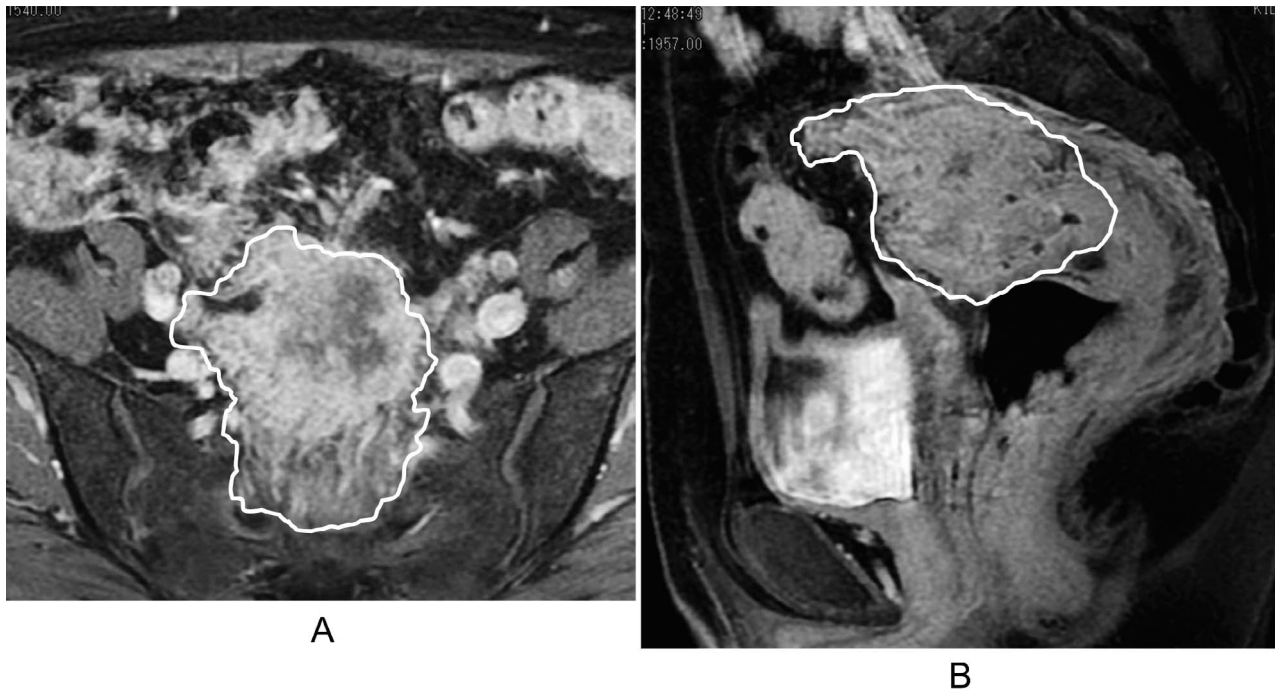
(A) Enhanced MRI demonstrated a tumor that expanded to the mesentery and retroperitoneum (white line forms the border). (B) Sagittal view of MRI: A giant mass expanded to the sigmoid colon and rectum (white line forms the border).
